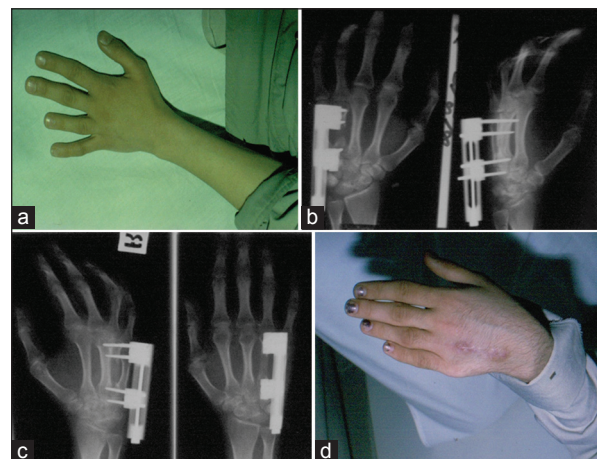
Distraction osteogenesis in 4th brachymetacarpia. (a) Preoperative photo. (b) Radiograph following device insertion. (c) Radiograph at the completion of the distraction. (d) Postoperative photo
